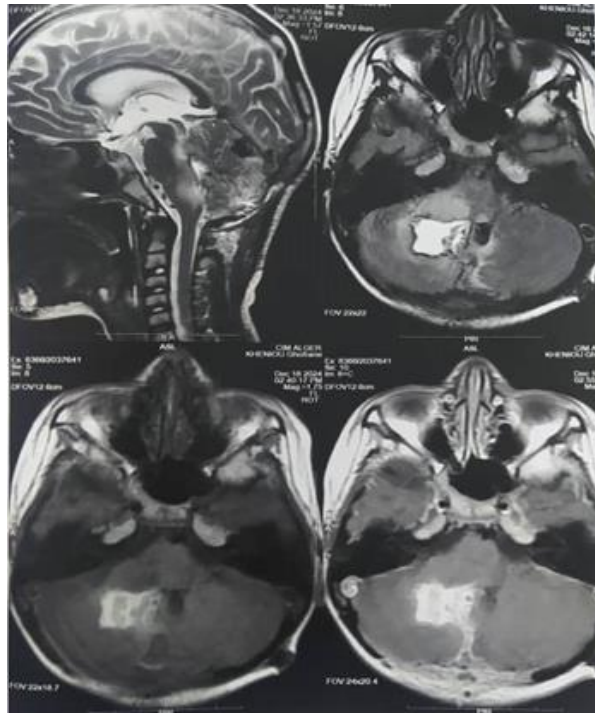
Post operative magnetic resonance imaging showing an intracavity hematoma with residual tumor infiltrating the brainstem.
